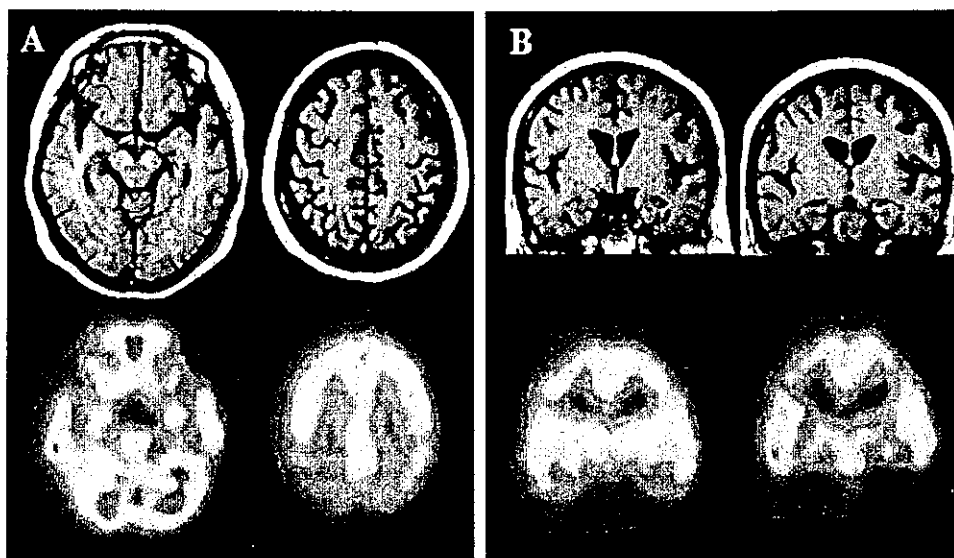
MRI (T1 weighted image) and SPECT ( $^{99m}\text{Tc}$ -ECD) findings. (A) Axial T1 weighted images show apparent occipito-parietal atrophy and mild atrophy in internal portion of temporal lobes. Axial SPECT images show marked hypoperfusion in bilateral occipito-parietal areas and internal portion of temporal areas. (B) Coronal images show slight atrophy in bilateral hippocampal areas, whereas coronal SPECT images show apparent hypoperfusion in the internal portion of temporal areas including bilateral hippocampal areas.
